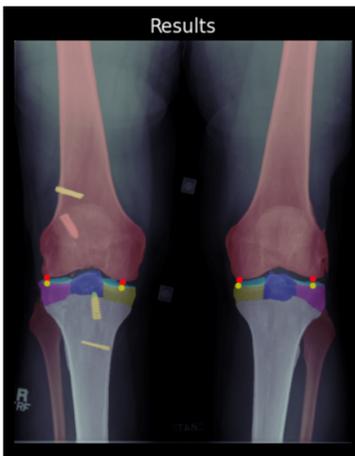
Segmentation map of weightbearing AP knee radiographs demonstrating the measured minimum joint space
